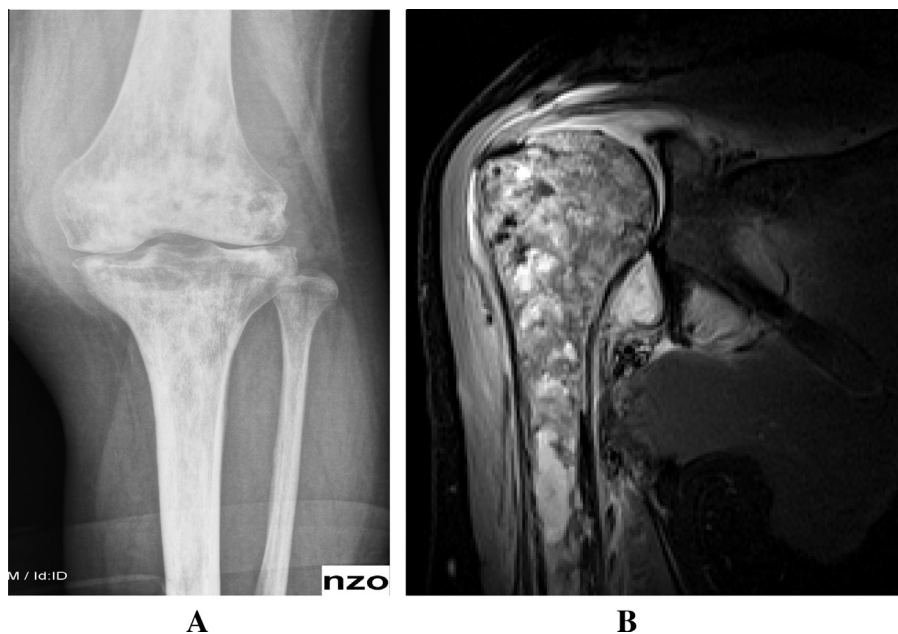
(A) X ray AP of knee joint showing distal femoral and proximal tibial metaphyseal sclerotic patches. (B) Coronal STIR MRI of right shoulder showing extensive humeral head, metaphysis and upper shaft heterogeneous signal intensity, both due to osteonecrosis.
